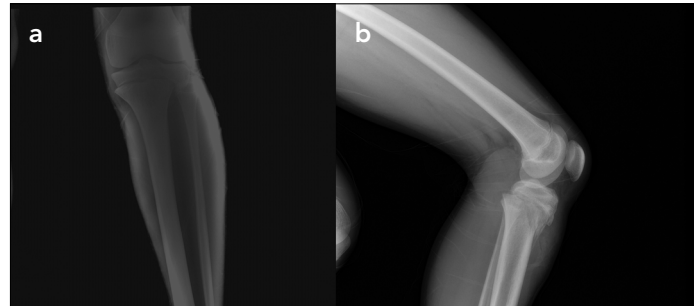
a, b. Direct radiography of the first case after trauma
